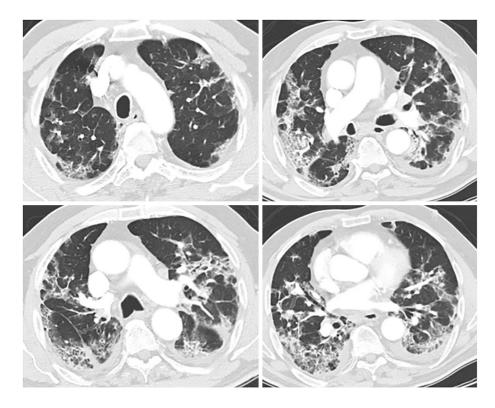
High resolution computed tomography images of a severe coronavirus disease 2019 patient showing the bilateral fibroreticular infiltrates with crazy-paving pattern.
